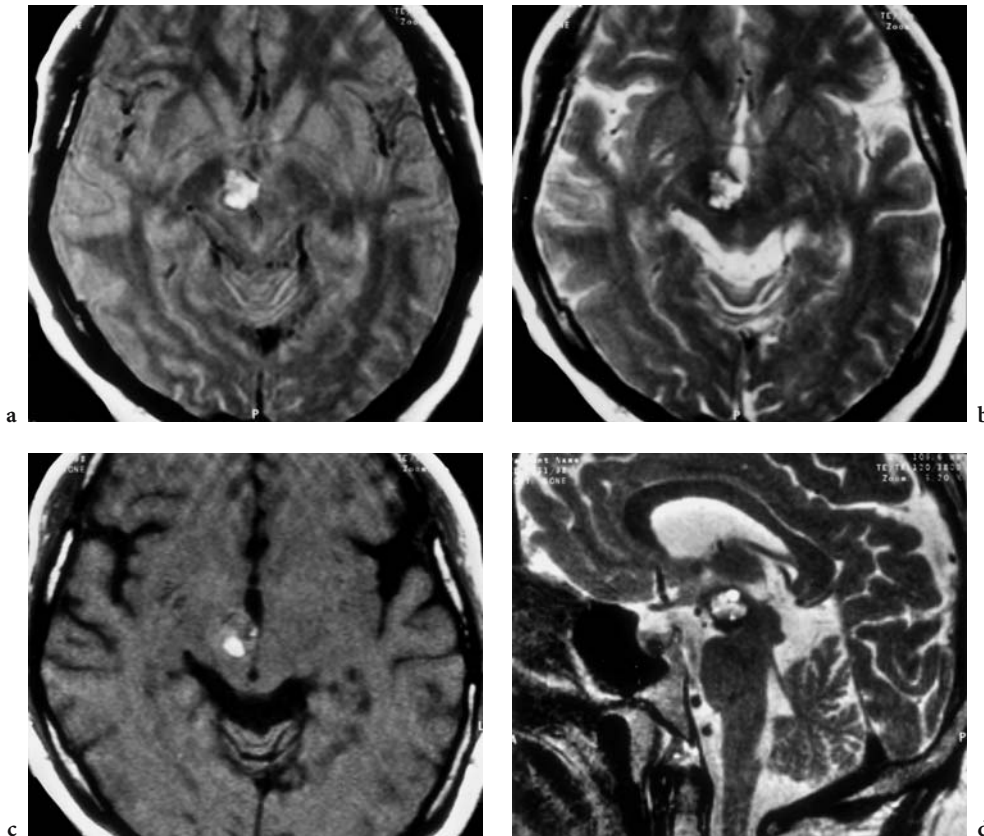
A 22-year-old woman with recurrent diplopia for both lateral views, presenting with acute right NIII paresis that resolved completely after 6 weeks. Diagnosis: mesencephalic cavernoma (history of four hemorrhages). MRI: a Axial proton density view, the high signal demonstrating the presence of blood (methemoglobin) in the cavernoma of the right cerebral peduncle. Note the symmetric formation of the substantia nigra. b Corresponding T2-weighted image, more clearly demonstrating the hypointense rim of hemosiderin confirming former hemorrhage. Note the slight suppression of the medial part of the third ventricle. c Corresponding T1-weighted native image where the hyperintensity represents a small cyst, filled with thrombotic material (hemosiderin), confirming subacute hemorrhage. d Right paramedian sagittal T2-weighted view demonstrating the entire width of the lesion. (With permission of Dr. Müller-Forell, Institute of Neuroradiology, Medical School, Mainz)
